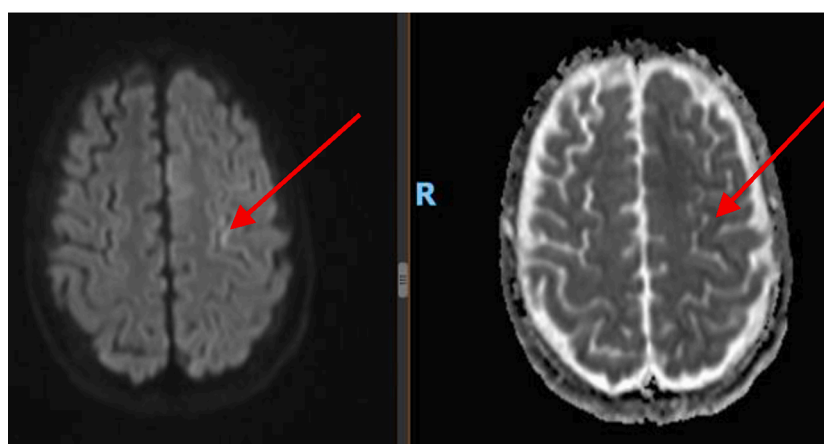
MRI brain with DWI (diffusion-weighted imaging) and ADC (apparent diffusion coefficient) showing diffusion restriction in (A) left thalamus and cortical gray matter near the left parieto-occipital junction, (B) median left parietal lobe, and (C) left frontal cortical gray matter.
